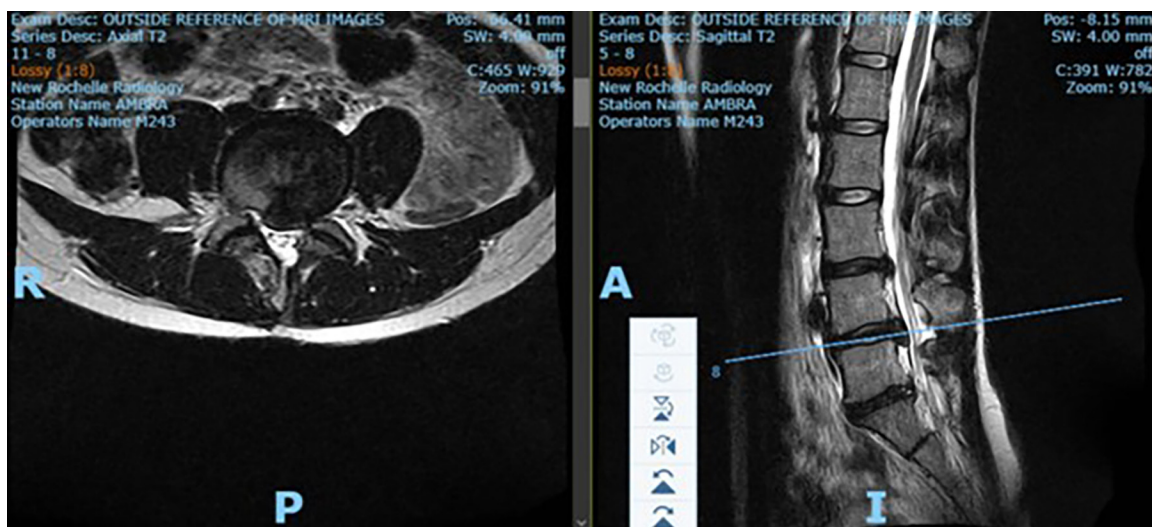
Lumbar MRI from June 2024.
